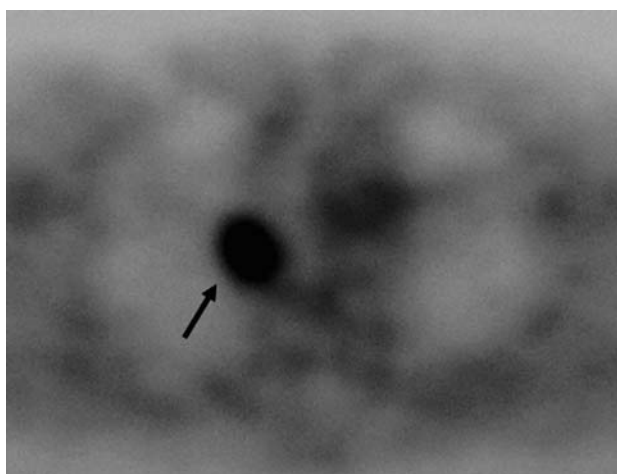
A positive result of positron emission tomography of a solitary pulmonary nodule that was also seen on chest computed tomography and that was later identified as a squamous cell carcinoma. The arrow indicates the malignant nodule.
